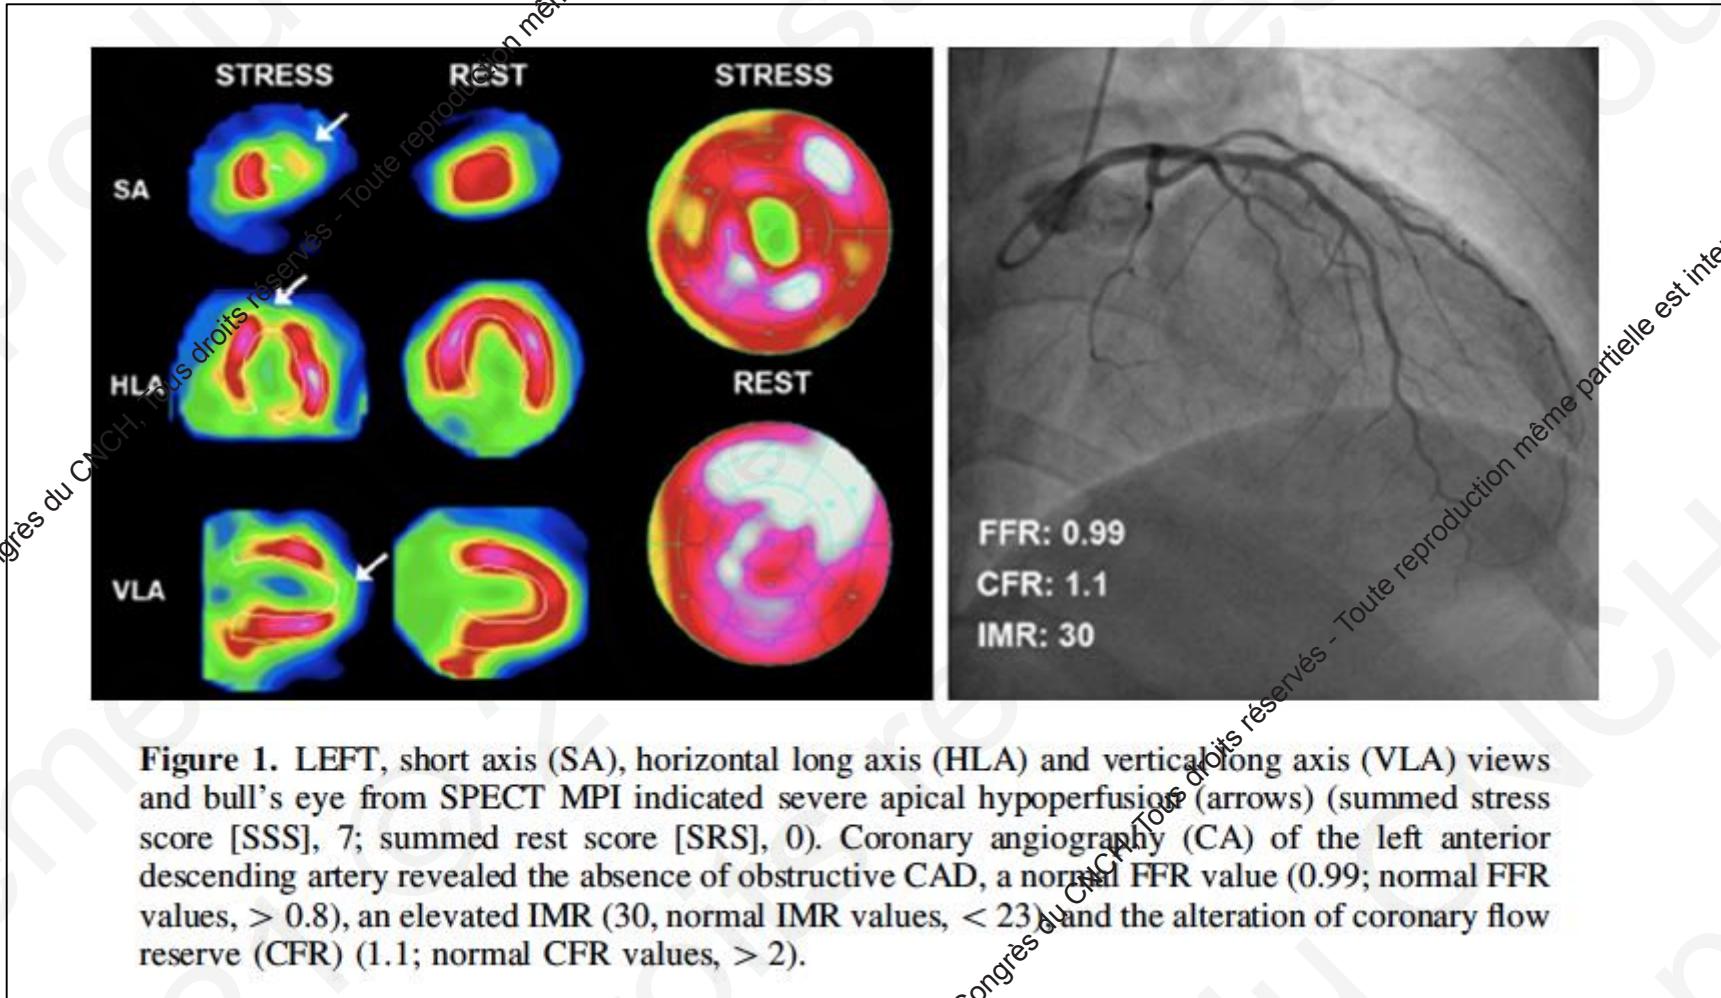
LEFT, short axis (SA), horizontal long axis (HLA) and vertical long axis (VLA) views and bull's eye from SPECT MPI indicated severe apical hypoperfusion (arrows) (summed stress score [SSS], 7; summed rest score [SRS], 0). Coronary angiography (CA) of the left anterior descending artery revealed the absence of obstructive CAD, a normal FFR value (0.99; normal FFR values, > 0.8), an elevated IMR (30, normal IMR values, < 23) and the alteration of coronary flow reserve (CFR) (1.1; normal CFR values, > 2).
